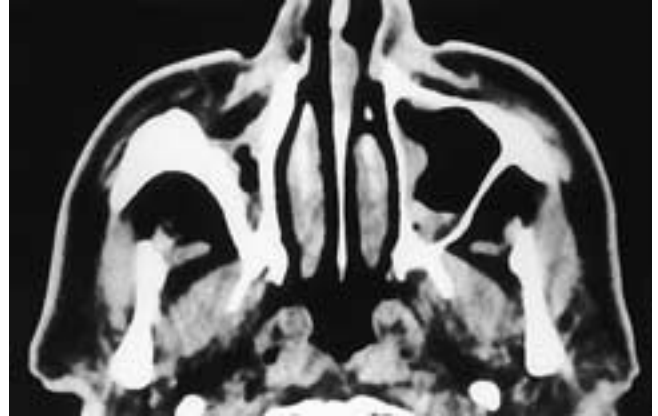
Axial CT scan shows a patient after a right Caldwell-Luc procedure. Fat from the cheek has partially prolapsed into the defect, and some inflammatory mucosal thickening is present bilaterally.
